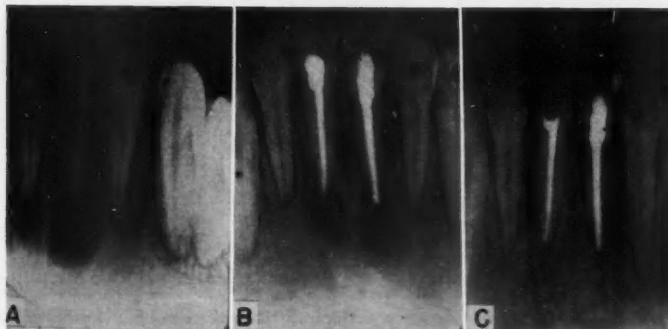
Two mandibular incisors with putrescent pulps and rarefied periapical areas. Pulp cavities of both teeth contained thick, foul-smelling pus. A, Before treatment; B, immediately after treatment; C, 3½ years after treatment.
